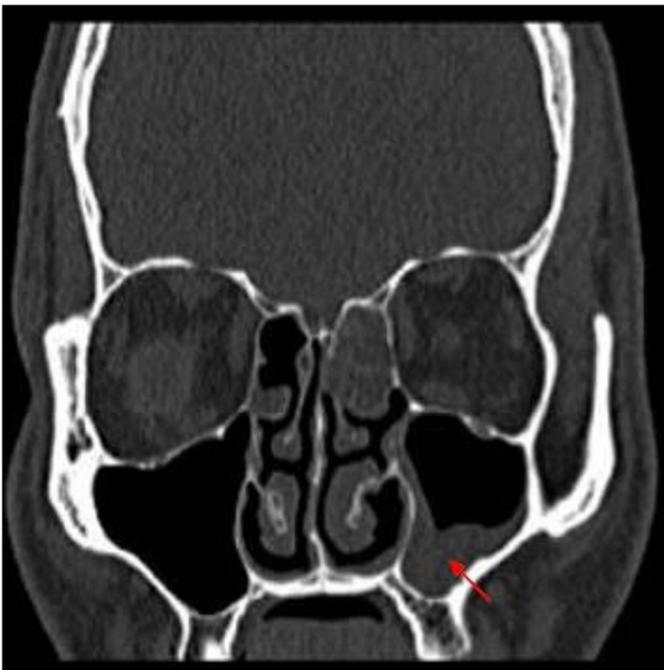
Preoperative coronal CT image showing unilateral mucosal thickening in the base of the maxillary sinus on left side (arrow).
